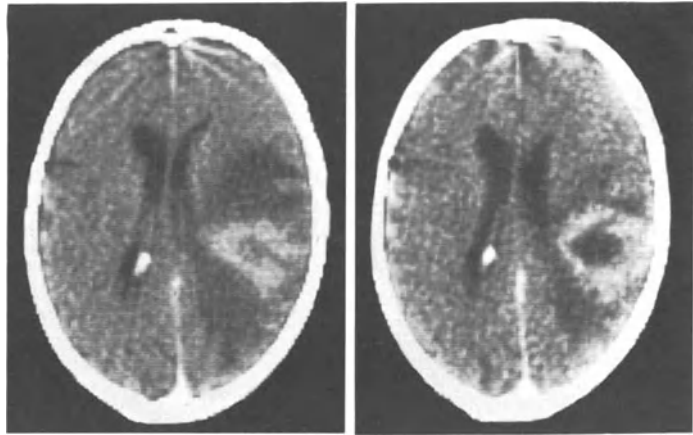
CT showing decrease of brain edema associated with a right-sided parietal glioma following combination therapy (dexamethasone 4x4 mg i.m./die and furosemide 3x40 p.o./die) for 13 days
